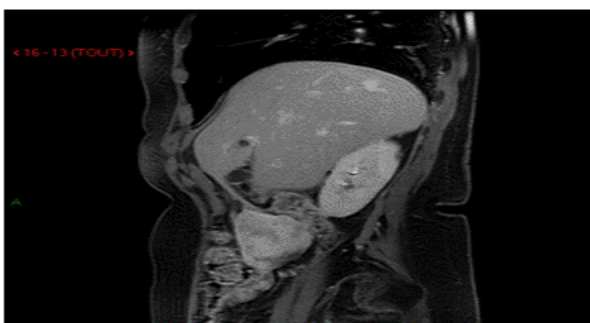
Sagittal gadolinium-enhanced T1-weighted image: Well defined pedicle connecting the mass to segment IVb of the liver (arrow).
